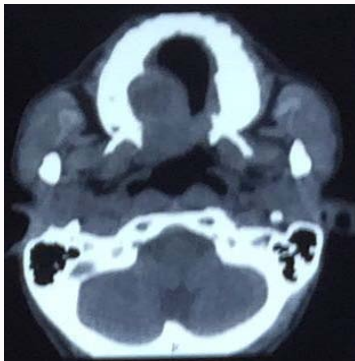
Axial section of noncontrast computed tomogram showing soft tissue mass over right side hard palate.
